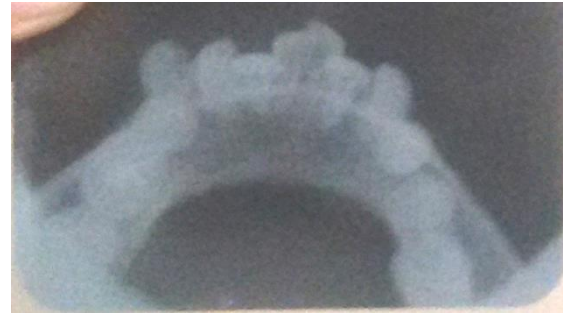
Occlusal radiograph showing thickening of buccal and lingual cortical plates of mandible on the left side
